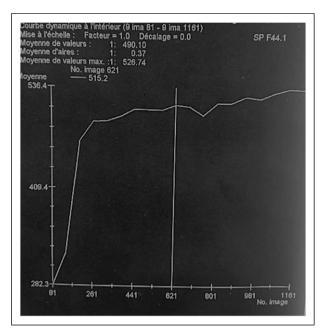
Diffusion MRI showing a type [C] curve related to a low
